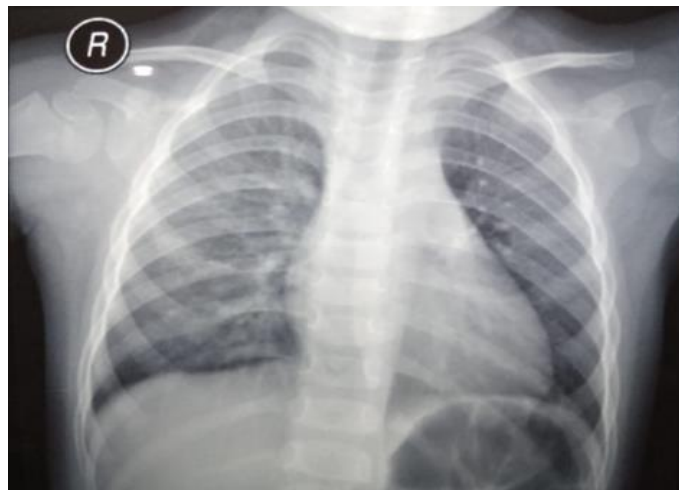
Patient's X-ray showing infiltrates in the right lung field.
